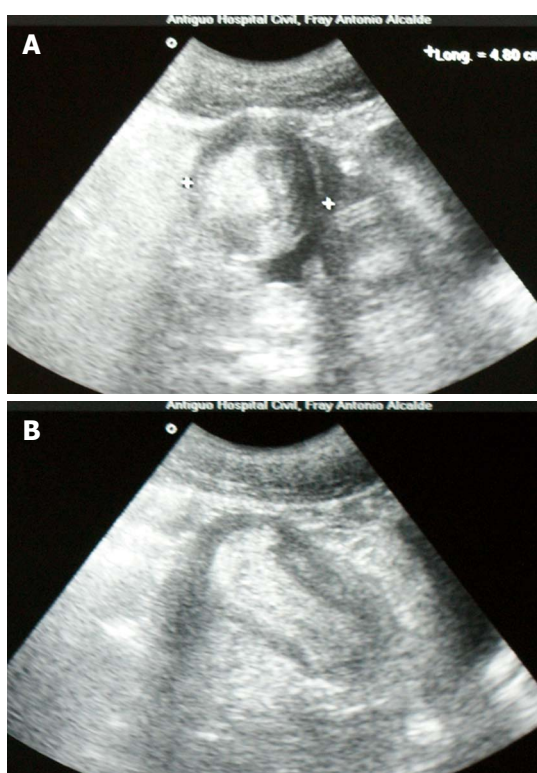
Ultrasonographic feature of a “target” sign on a transverse view (A), and a “sausage-shaped image” in a longitudinal view (B).
